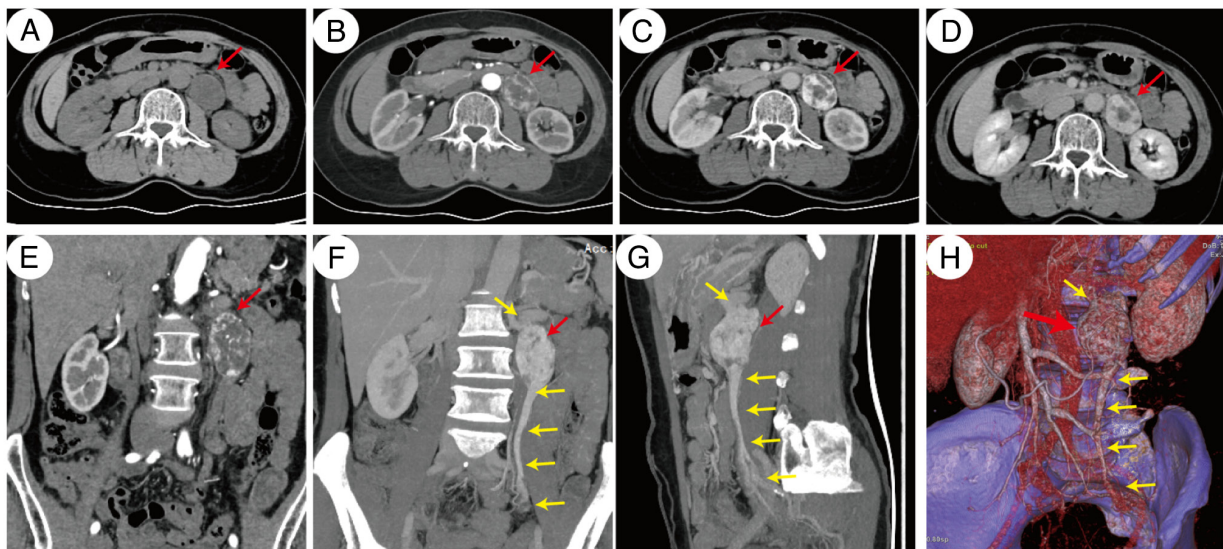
CT images of the retroperitoneal mass. (A) Plain scan. (B) Arterial phase. (C) Venous phase. (D) Delayed phase. (E) CT enhanced coronal image shows the range of the mass and its relationship with adjacent structures (red arrow). (F) CT enhanced coronal image showing the association between the mass (red arrow) and the ovarian vein (yellow arrow). (G) Sagittal maximum intensity projection image showing the association between the mass (red arrow) and the ovarian vein (yellow arrow). (H) 3D reconstructed image shows the mass (red arrow) connecting the left ovarian vein (yellow arrow) at its upper and lower poles, joining the left renal vein.
